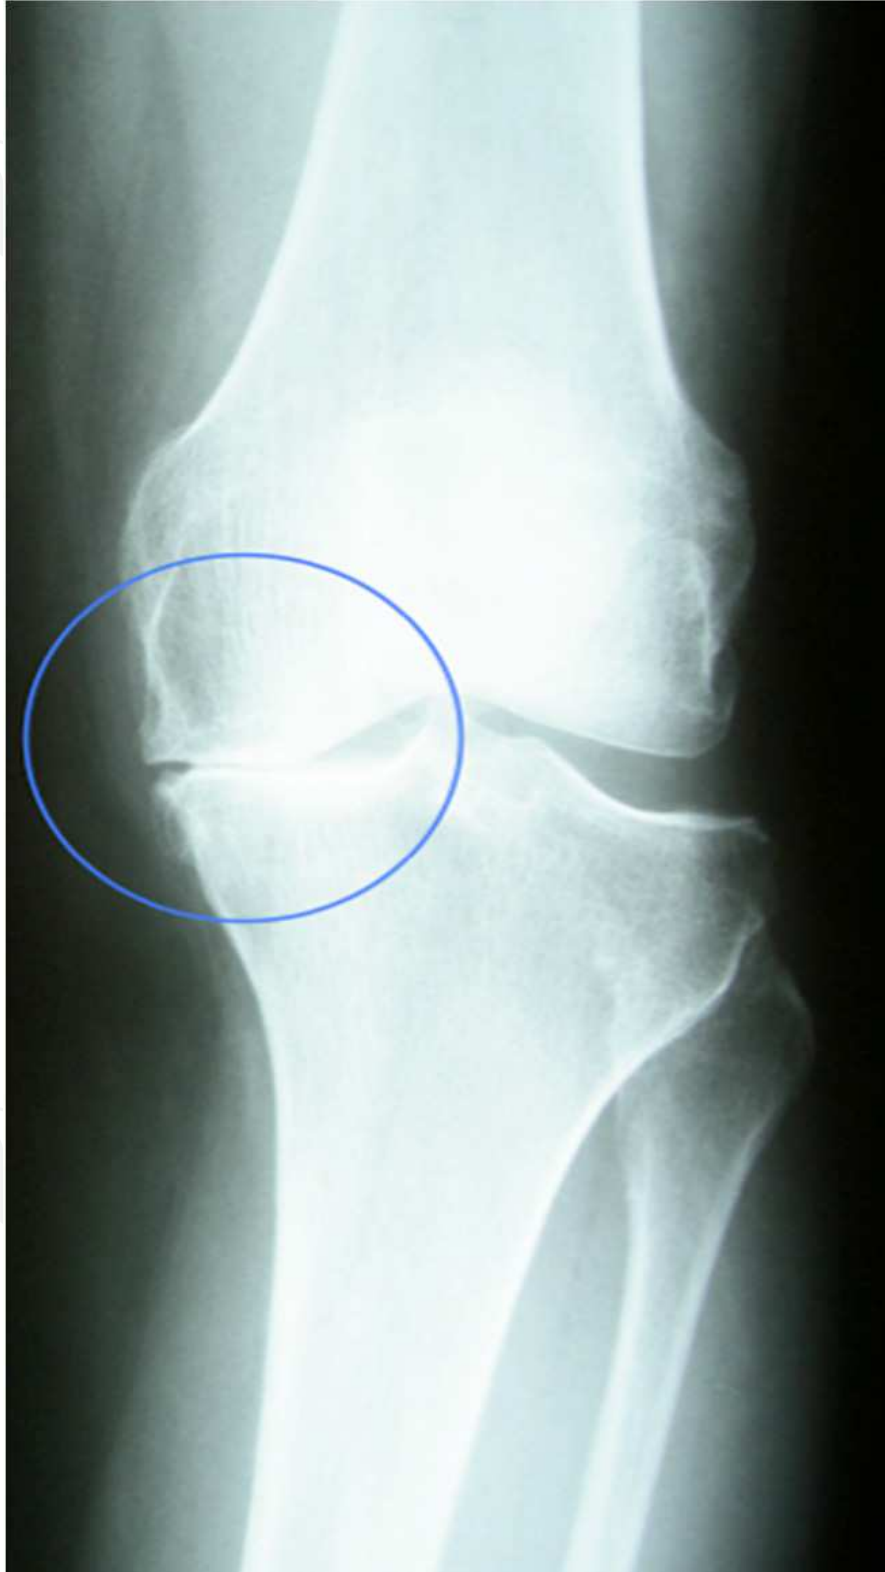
Radiography of the knee with medial osteoarthritis and varus deformity
